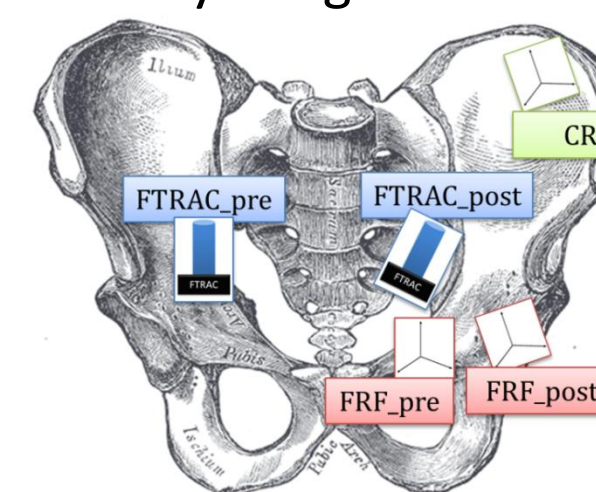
X-ray navigation coordinate frames.
